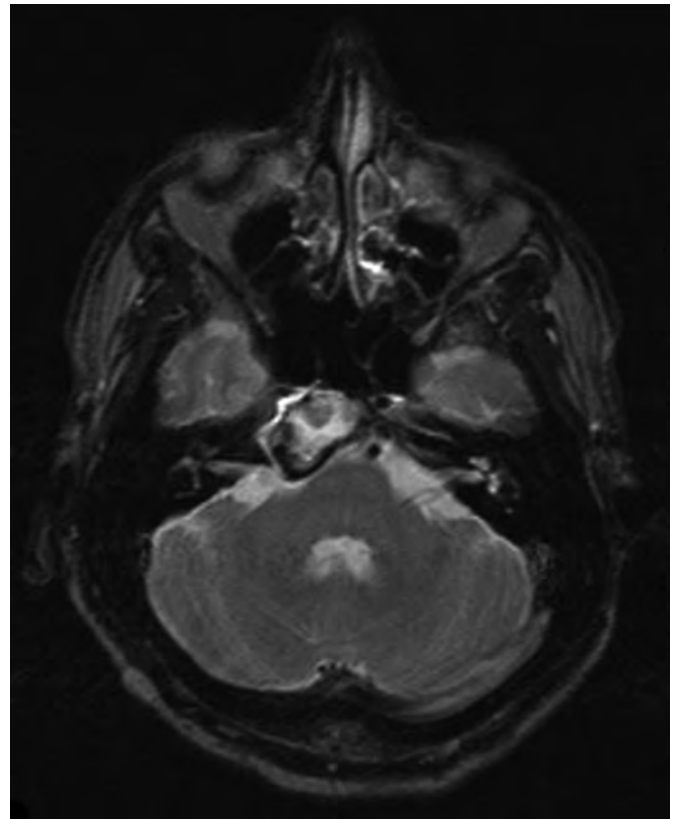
Axial T2-weighted magnetic resonance imaging demonstrating the right clival-based lesion causing mild compression of the pons.
